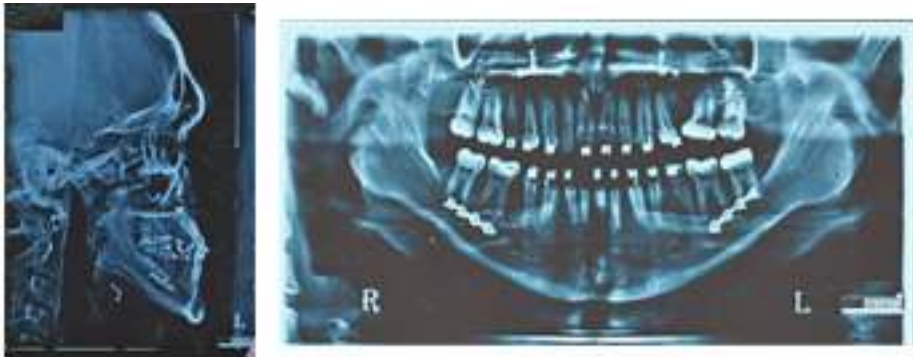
18 months postoperative radiographs
